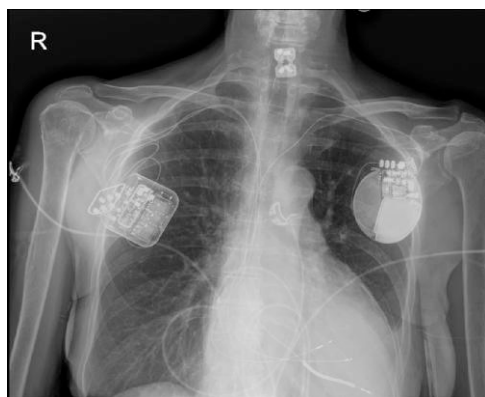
Chest radiograph after cardiac contractility modulation-implantation with two leads: local sense and right ventricular lead implanted in the right ventricular septum. The cardiac contractility modulation device is implanted at the right side and implantable cardioverter-defibrillator at the left side of the patient.
